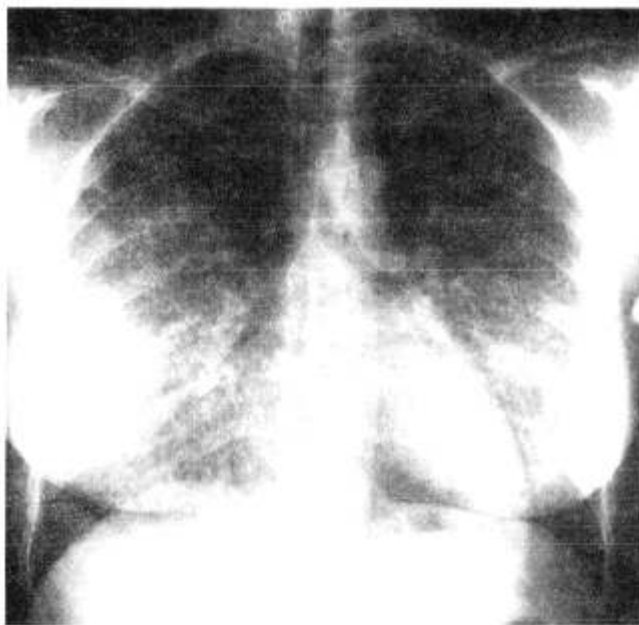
Chest roentgenogram of patient 2 prior to lavage. A cryptococcoma is visible on the pleural surface of the right upper lobe.
